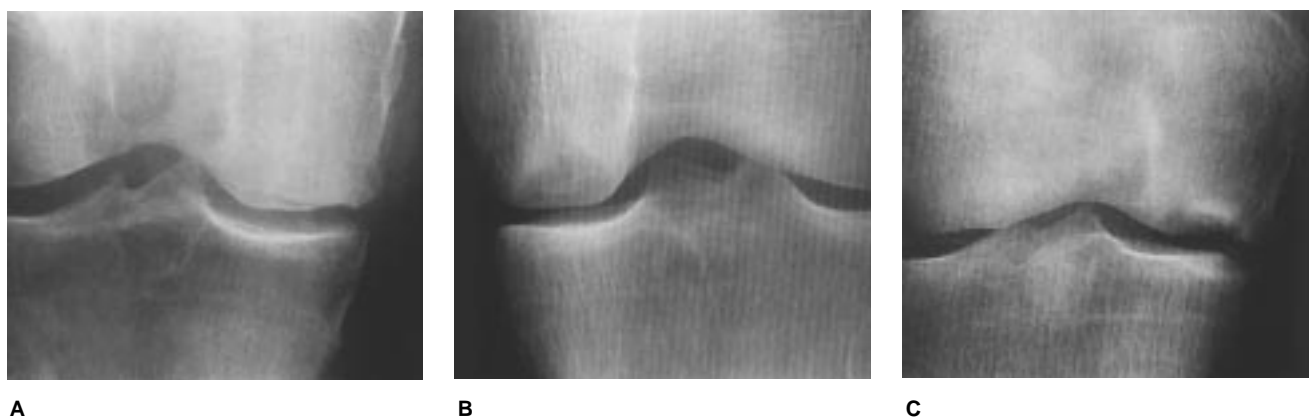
Plain-radiographic appearance of stages of spontaneous osteonecrosis of the femoral condyle. A, Stage 2 lesion with flattening of the medial femoral condyle and subchondral lucency. B, Stage 3 lesion with radiolucency surrounded by slight sclerosis. C, Stage 4 lesion with collapse of the articular surface.
